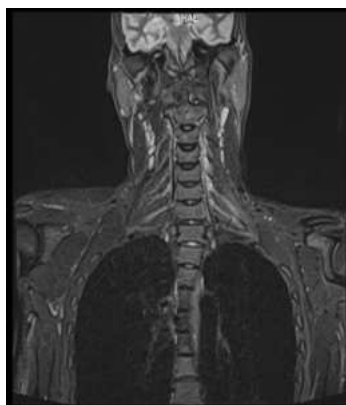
MRI of the brachial plexus shows enhancement of the C4, C5, C6, and C7 roots on both sides, with greater enhancement of the C6 root on the left side.
